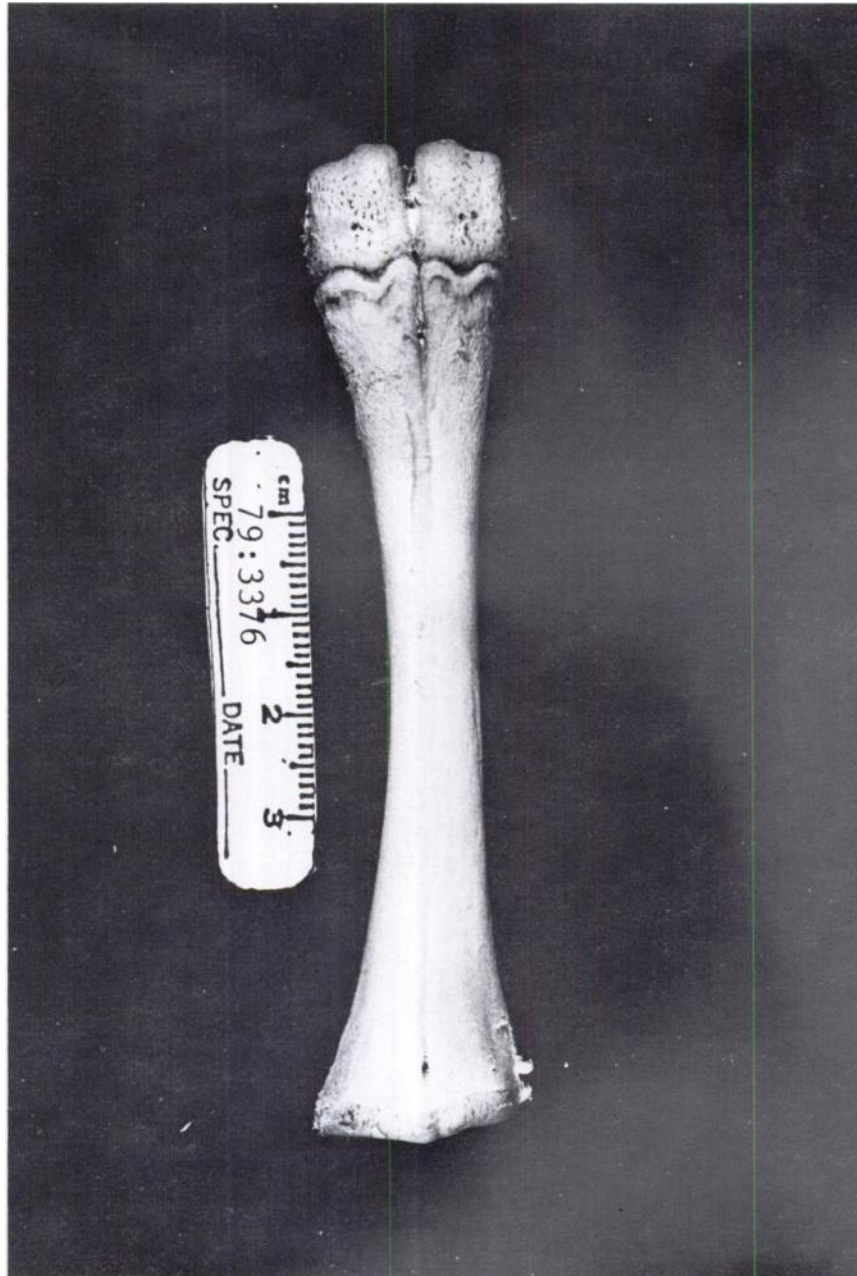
The palmar view of the right metacarpal bone failed to demonstrate the marked deviation of the medial metacarpal bone which was evident radiographically.
